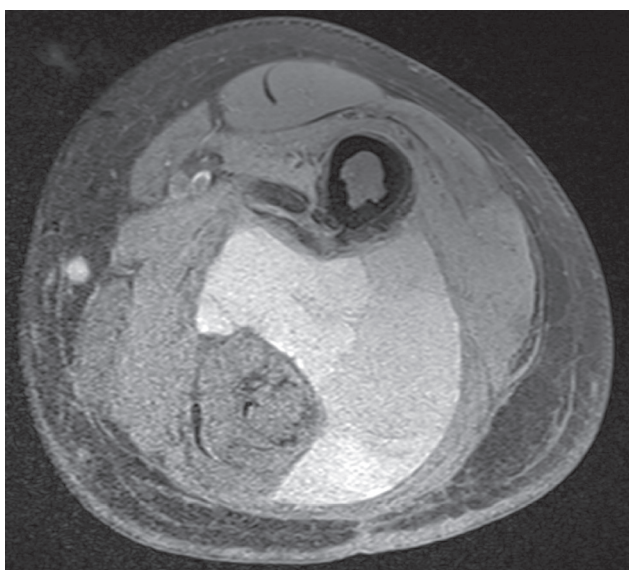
Post-operative MRI after surgical resection reveals large posterior thigh seroma (axial fat-saturated proton density sequence)
